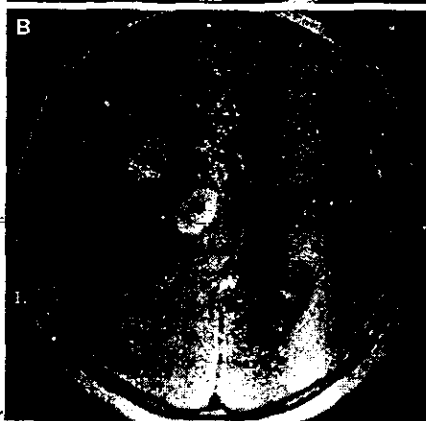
T1-weighted magnetic resonance images with gadolinium enhancement of the brain showing the lesions. A and B, axial images; C, coronal image.
